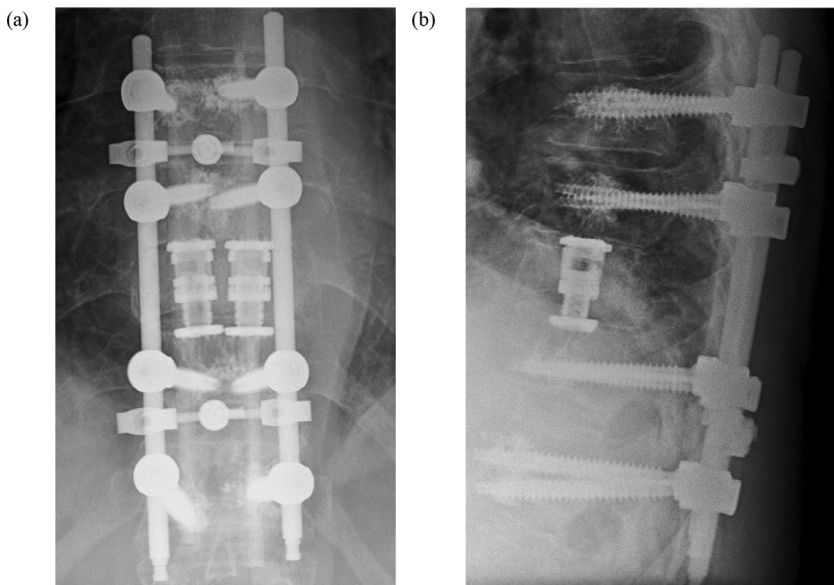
AP (a) and lateral (b) radiographs of the thoracic spine showing bilateral expandable cage placement during vertebral body reconstruction.
